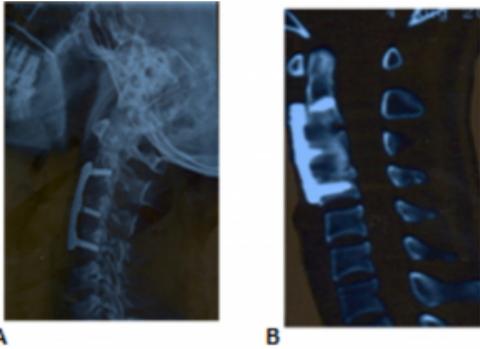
X-ray done fifteen months following surgery shows no implant complication (A). CT axial cut confirmed solid arthrodesis. .
